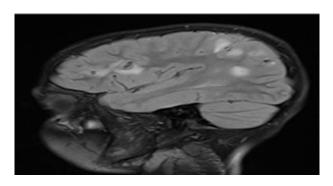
MRI brain T2W saggital image-shows multiple discrete hyperintensities in subcortical white matter.
